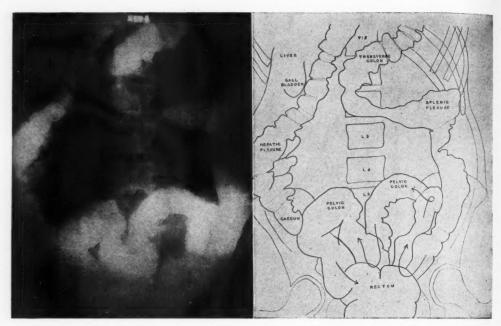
Radiograph of the colon, patient prone. In the erect position the colon was in practically the same position.
